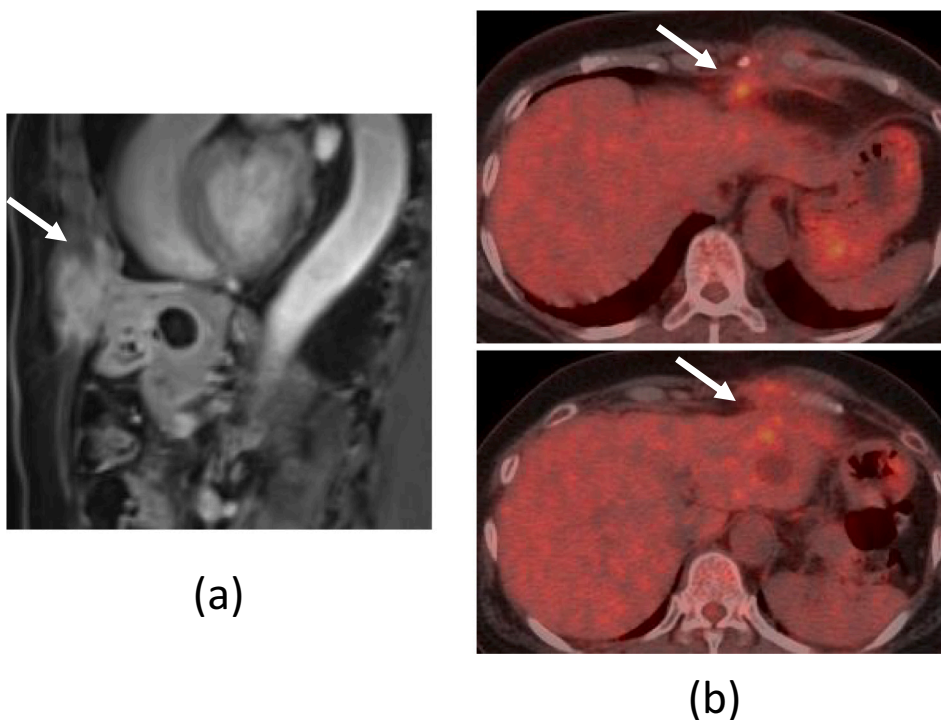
(a) The tumor showed high intensity on Magnetic resonance T2-weighted imaging. (b) Positron emission tomography-computed tomography with a glucose analogue, 18F-fluorodeoxyglucose, revealed pathological uptake in the tumor.
